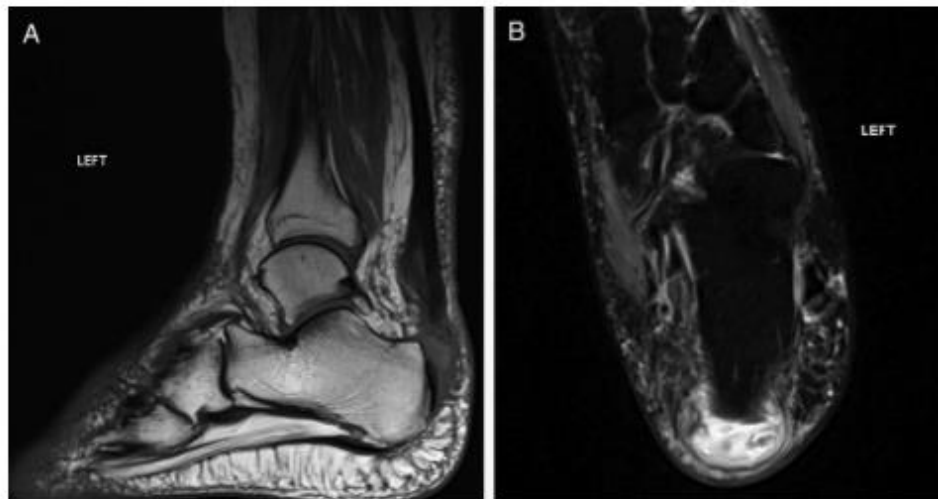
A patient-sustained Achilles tendon rupture 3 months after the coblation therapy. (A) This T1 magnetic resonance image is showing a 2.7-cm gap at the rupture site near the Achilles insertion. (B) An oblique axial, T2 magnetic resonance image shows a section void of Achilles tendon.
